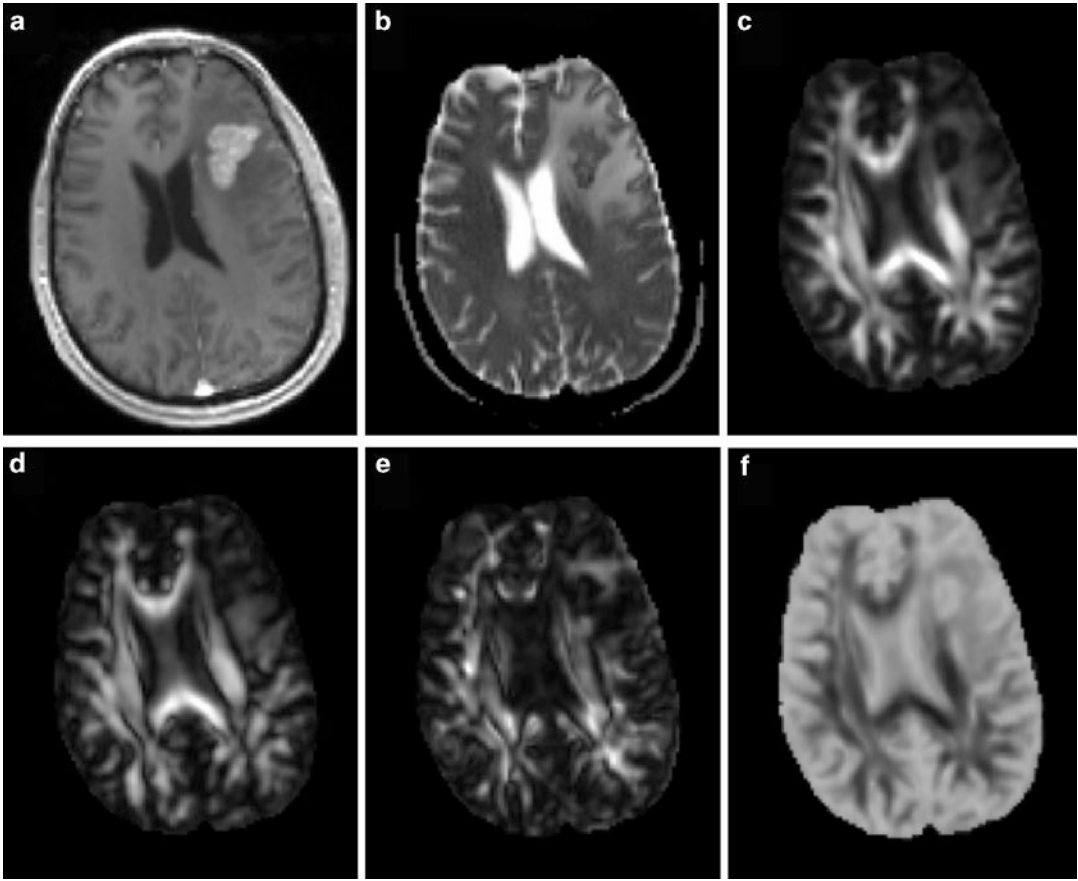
A 53-year-old male with metastatic lung adenocarcinoma in the *left* frontal lobe. Axial contrast-enhanced T1-weighted (a) shows a solid enhancing lesion. MD map (b) shows restricted diffusion of the enhancing part ($0.95 \times 10^{-3}/\text{mm}^2/\text{s}$). Lower FA (c), CL (d), and CP (e) are
